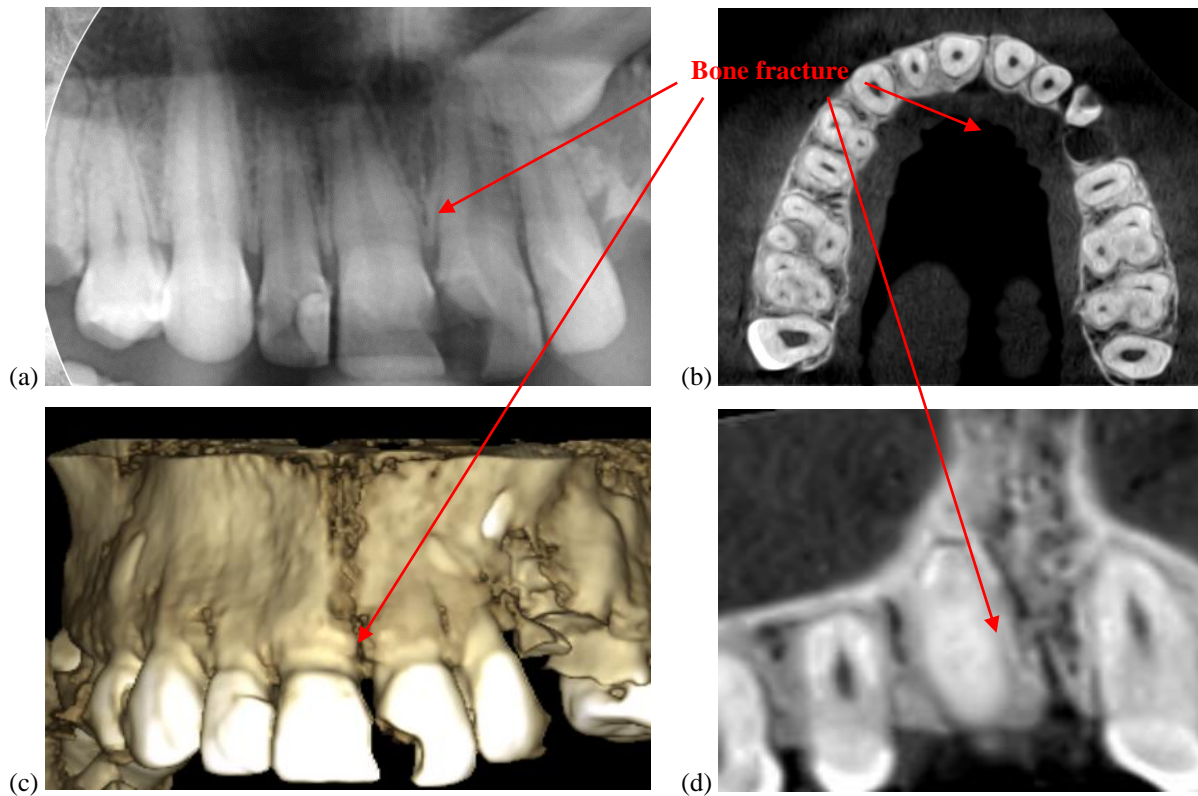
Images of maxillary fracture: (a) section of a panoramic radiography, (b) Axial view (on the z-axis) from 3D CBCT, (c) volumetric reconstruction, and (d) coronal view (on the y-axis) from 3D CBCT.
